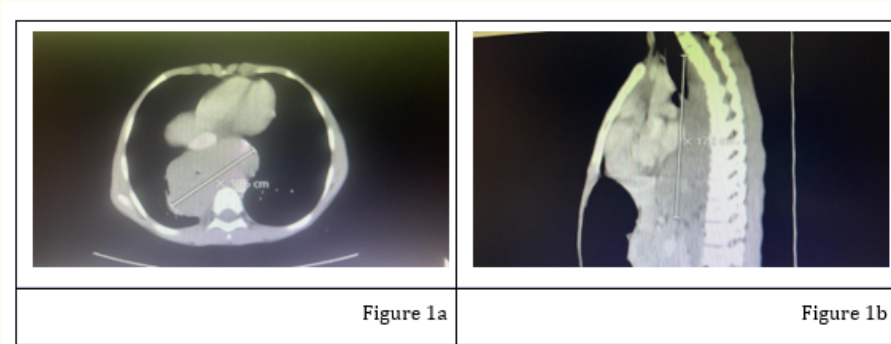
(a) Axial view CT scan showing a posterior mediastinal mass arising from the esophagus with maximal diameter 10.6 cm. (b) Sagittal view of the mass showing its maximal length 17.2 cm.
